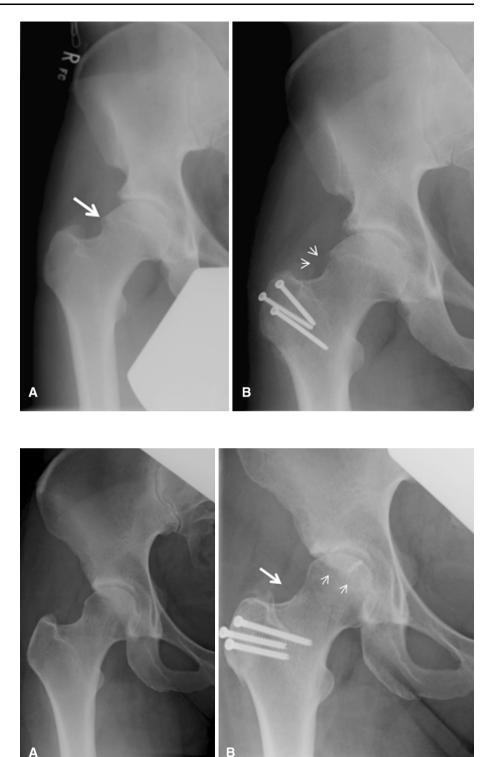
Pre (a)- and post (b)operative standard anteriorposterior radiographs are shown of a patient who underwent open surgical dislocation, acetabular rim trim, labral refixation, and femoral osteoplasty. The abnormal bone was resected on the edge of the femoral head (*arrow*), and the acetabulum was also trimmed back (*arrowhead*) to eliminate the abnormal contact
